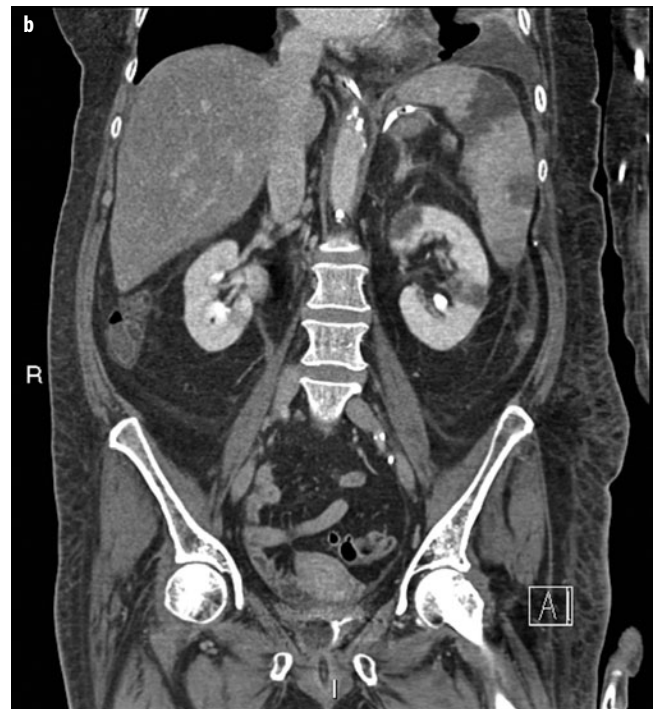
a, b. A 65-year-old woman with fever and bacteremia and known endocarditis. a Axial computed tomography (CT) image with IV-administered contrast shows acute infarction in the spleen due to septic emboli. There is a small, reactive left pleural effusion. b Coronal CT reformation shows the extent of splenic infarction and bilateral acute renal infarcts due to septic emboli, left larger than right
